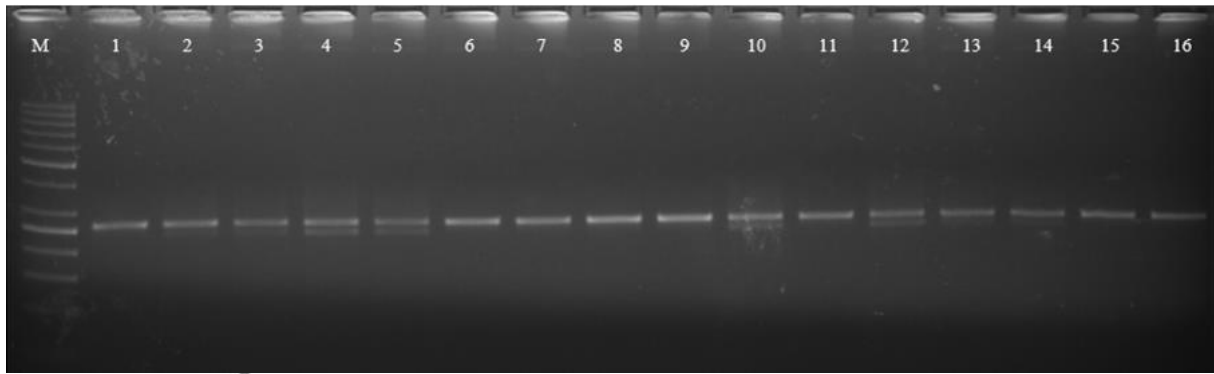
Digestion results of miR-34b/c gene polymorphism: The first well contains 50 bp marker (M). BccI enzyme digests 265 bp product to 235 bp and 30 bp when has C allele. 30 bp product cannot be seen in the figure. Wells that contain 265 bp product have TT genotype (i.e. 6. patient) and wells that contain 265 bp and 235 bp products have CT genotype (i.e. 4. patient). Results have not CC genotype in both patients and controls.
